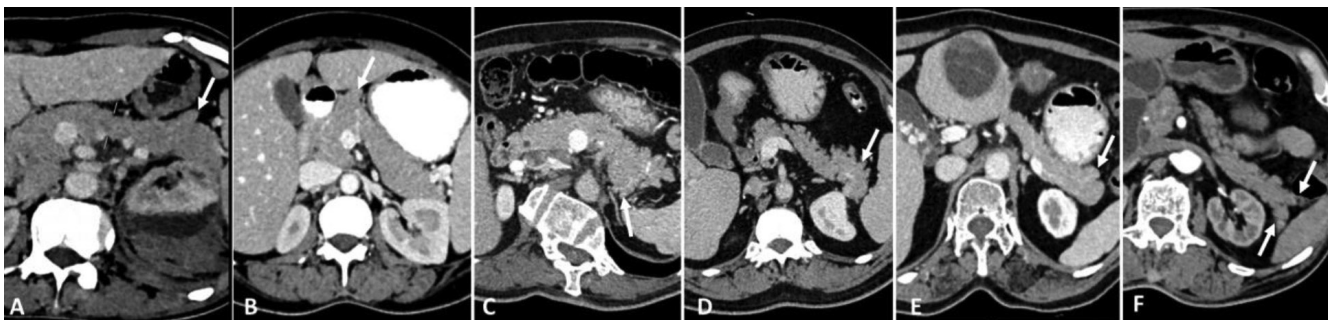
Contrast enhanced axial CT sections, portovenous phase showing various pancreatic contour and morphological variations. A: anterior lobulation in tail (white arrow) B: anterior lobulation in head (white arrow) C: Posterior lobulation in tail (white arrow) D: Lobulated morphology of tail (white arrow) E: Globular morphology of tail (white arrow). Note the incidentally detected Hydatid cyst in liver and cholelithiasis F: Bifid tail of pancreas (white arrows).
